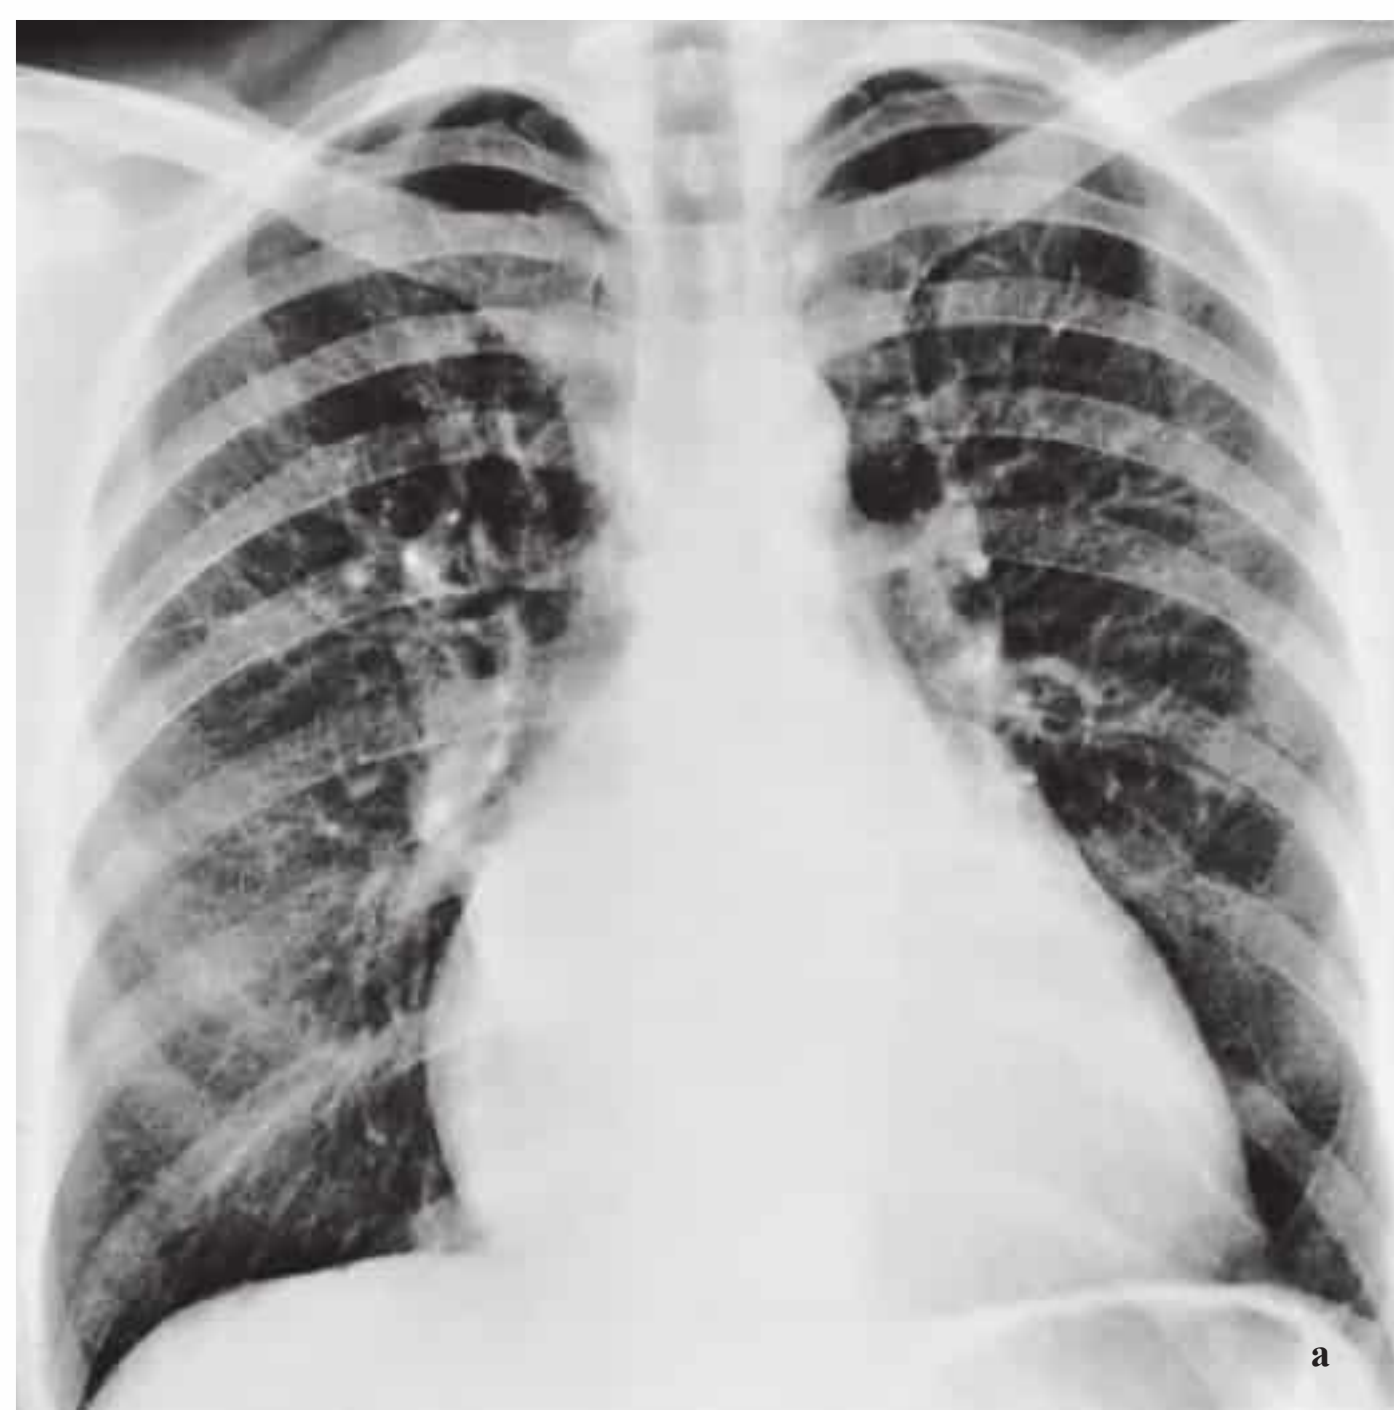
a, b Combined mitral valve defect with predominant stenosis. PA chest radiograph (a) and left lateral radiograph with an esophagogram (b). Enlargement of the left atrium is manifested by a double contour along the right cardiac border, a prominent atrial appendage, and deep indentation and posterior curving of the opacified esophagus.
